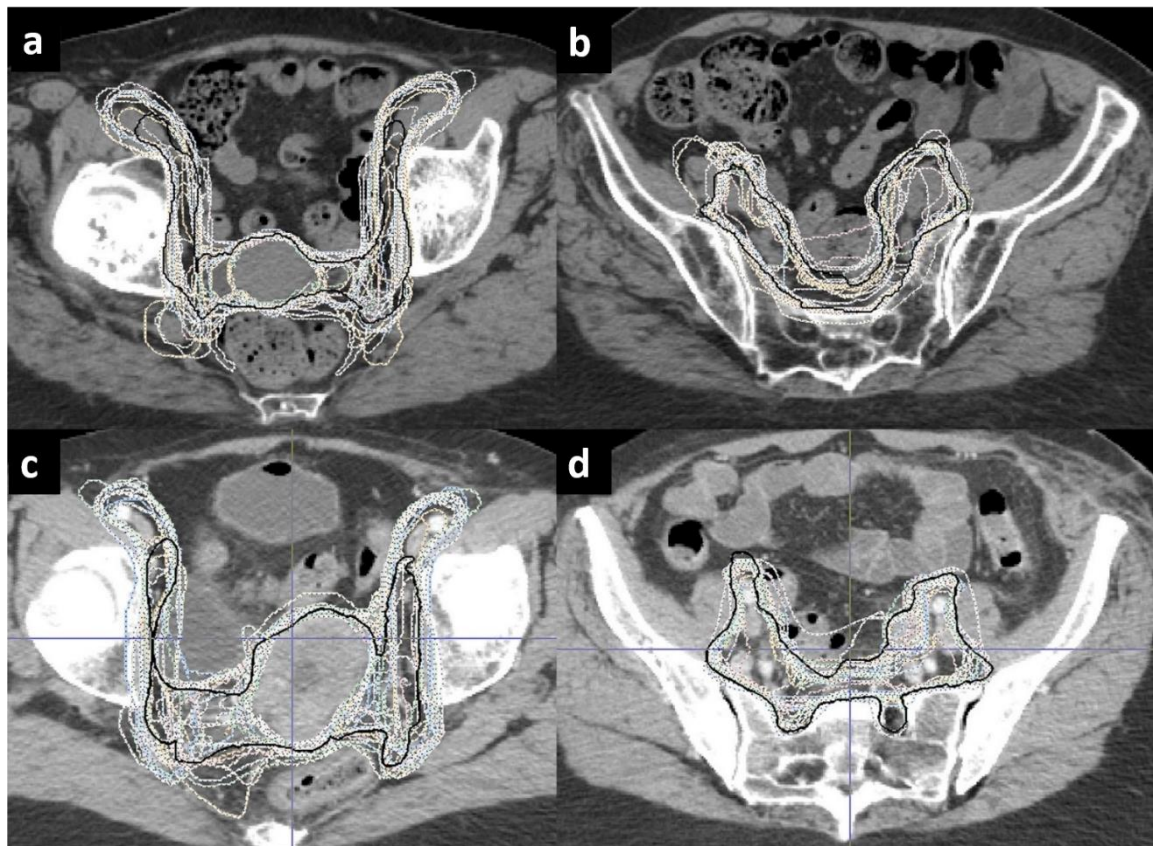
Transverse CT images of CTVs (white) and GSCTV1+2(black) for case 1 (a&b) and 2 (c&d) at sacro-iliac level (a&c) and superior to femoral heads (b&d).
